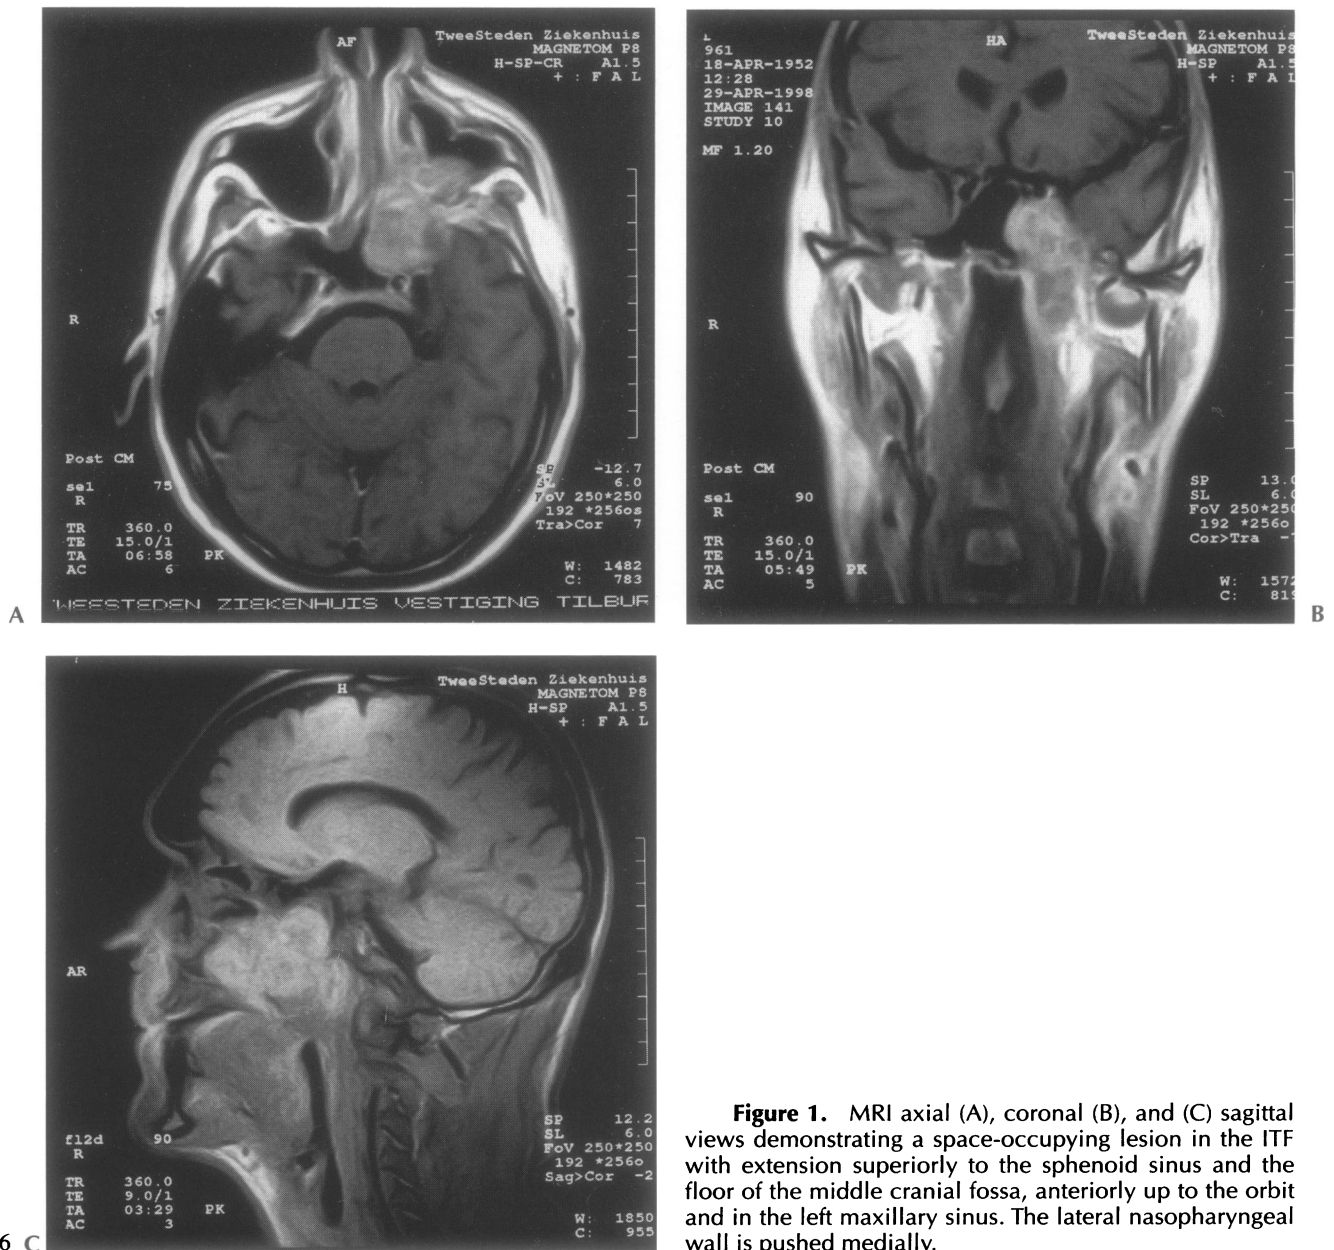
MRI axial (A), coronal (B), and (C) sagittal views demonstrating a space-occupying lesion in the ITF with extension superiorly to the sphenoid sinus and the floor of the middle cranial fossa, anteriorly up to the orbit and in the left maxillary sinus. The lateral nasopharyngeal wall is pushed medially.
